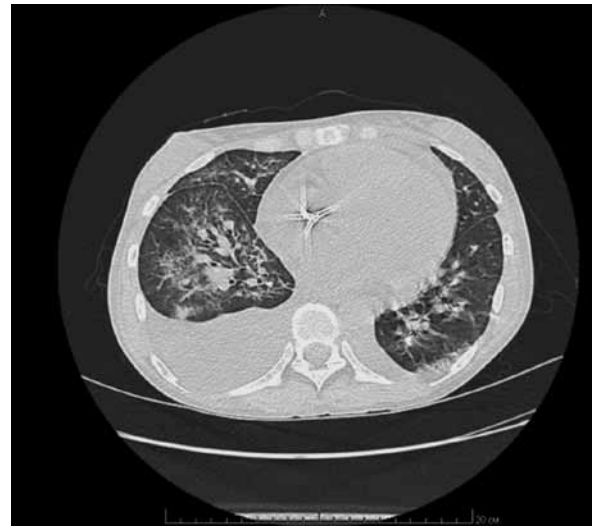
Chest CT scan dated December 6, 2021
